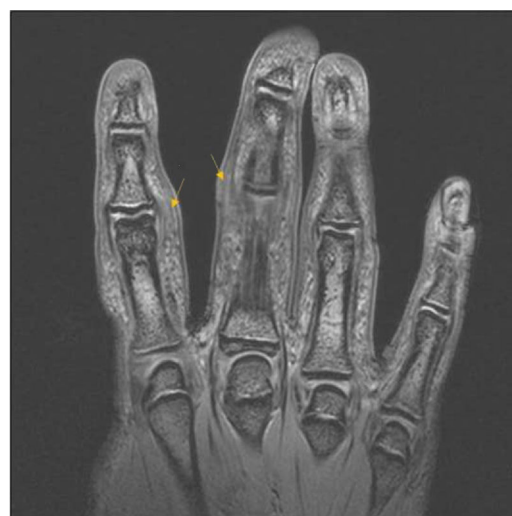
MRI of right hand, showing an increase in soft tissue with altered signal due to oedema of the second, third and fourth fingers (arrows).
